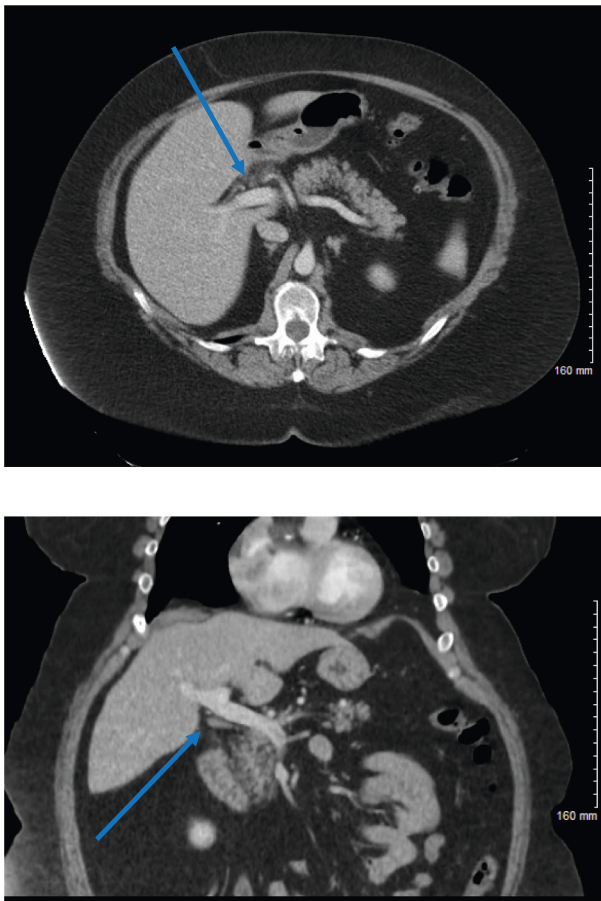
CT scan obtained postoperatively. No gallbladder identified in the gallbladder fossa (blue arrows).
